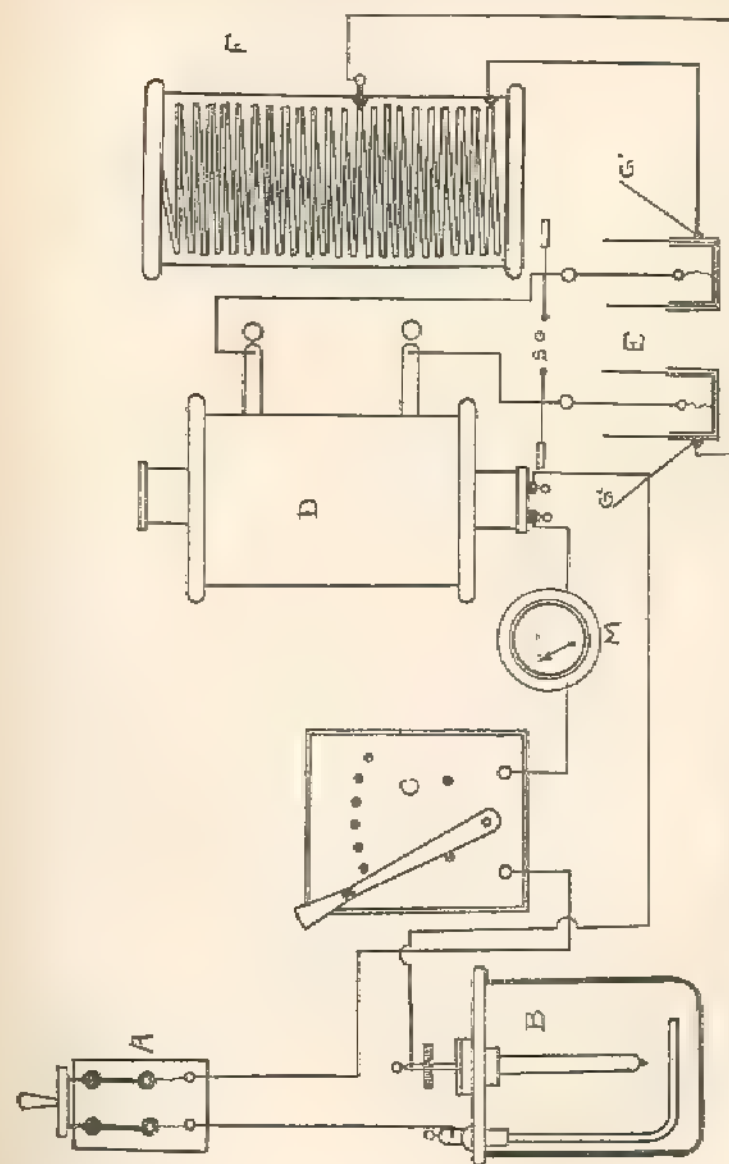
Complete Coil Equipment for High Frequency and X-Ray.
